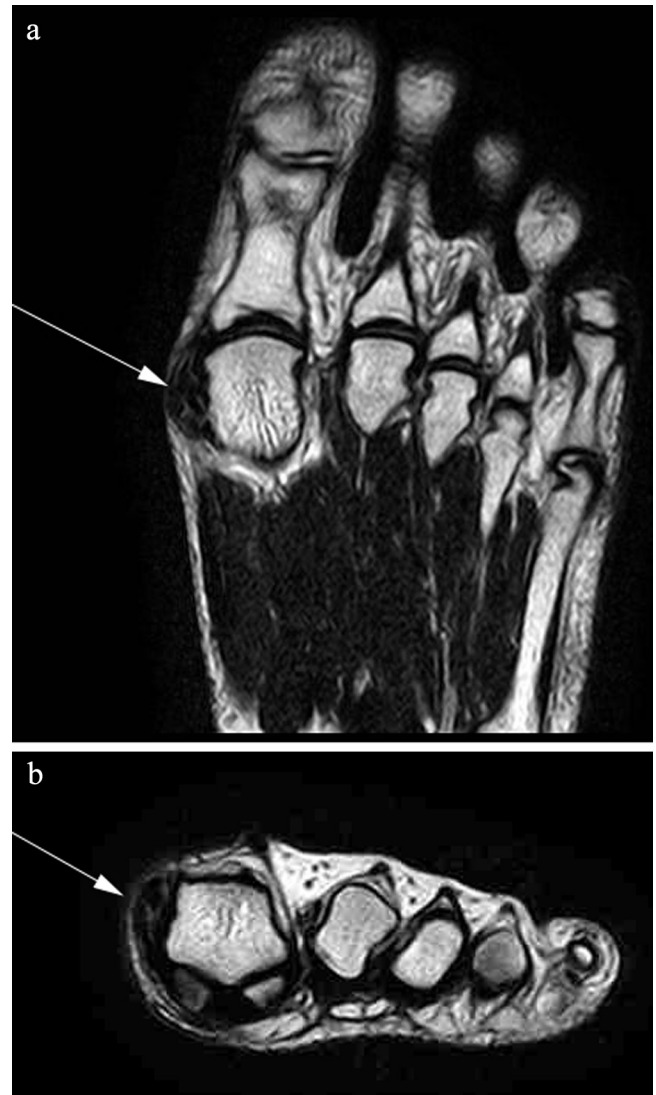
(a) Coronal T2-weighted MR images of the foot show a well defined mass including an ovoid-shaped dark signal nodule suggesting calcification (arrow) and peripheral intermediate signal intensity with low signal rim, in the juxta-articular area of medial aspect of first MTP joint. (b) Axial T2-weighted MR images of the foot show a well defined mass including an ovoid-shaped dark signal nodule suggesting calcification (arrow).
